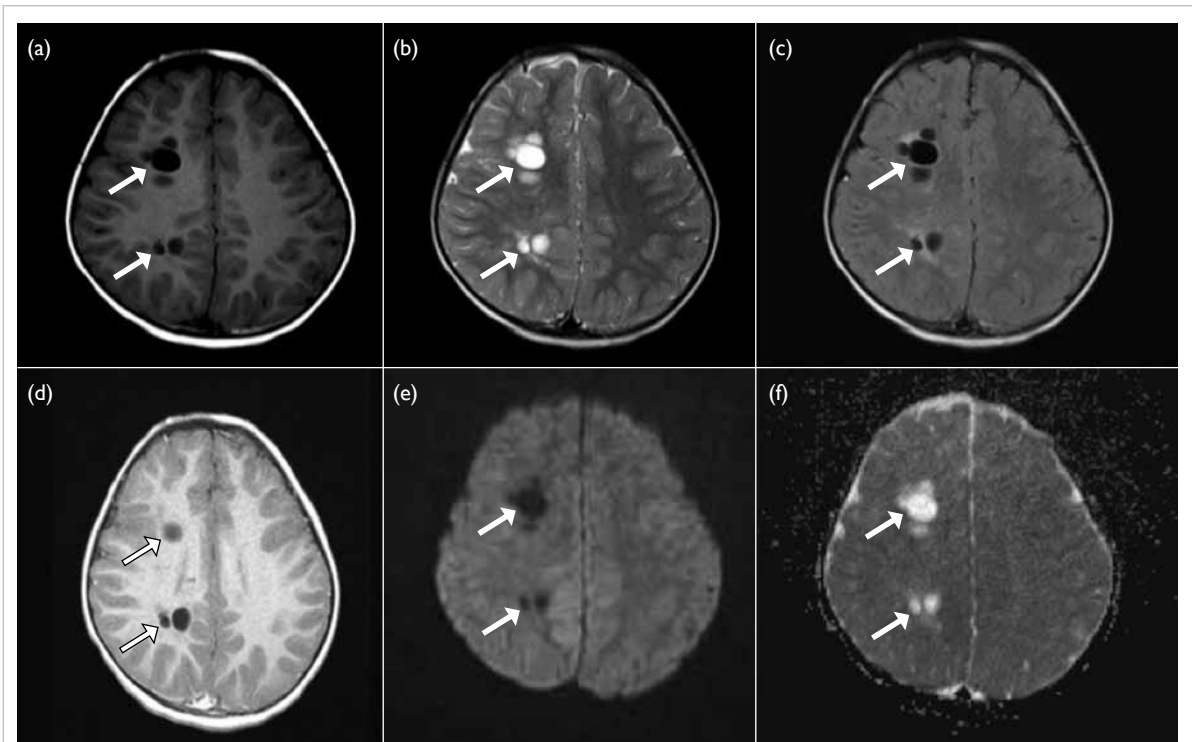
Magnetic resonance imaging (MRI) on day 2 following admission at the level of the right parietal lobe lesions
